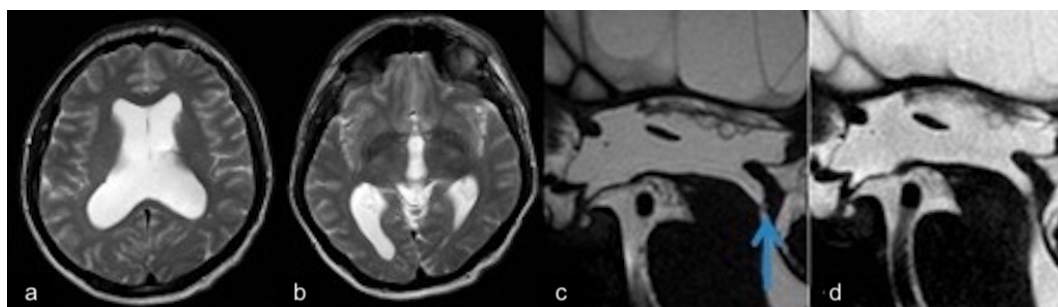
CSF Flow MRI image of a patient with an aqueductal web. There is chronic hydrocephalus in the lateral ventricles (a) and third ventricle (b) on T2-weighted images. (c) In the 3D Balanced Heavy T2 image there is membrane formation distal to the aqueduct (blue arrow). (d) No expected flow void area of aqueductal CSF flow in flow-sensitive T2 DRIVE sequence.
